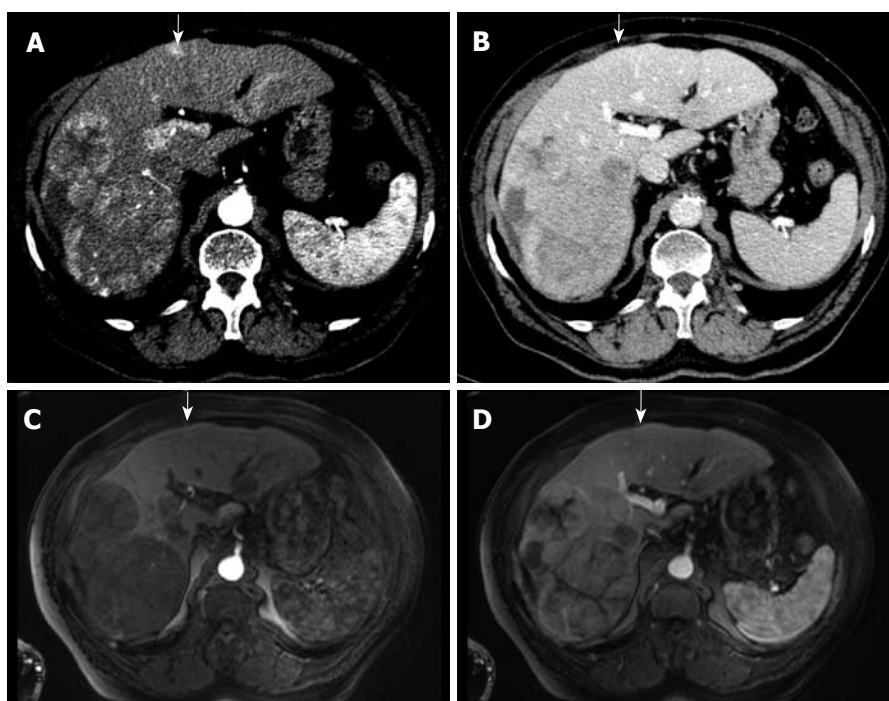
82-year-old man with biopsy-proven HCC. Detection of an additional tumour nodule by MDCT. The contrast-enhanced arterial phase MDCT demonstrates large tumours in the right liver lobe and one additional hypervascularized nodule in segment 4 (A, arrow) but not in the portal venous phase (B, arrow). Contrast-enhanced MRI depicts the large tumours in the right liver lobe but not in segment 4 (arrows) in early arterial phase (C) and portal venous phase (D).
